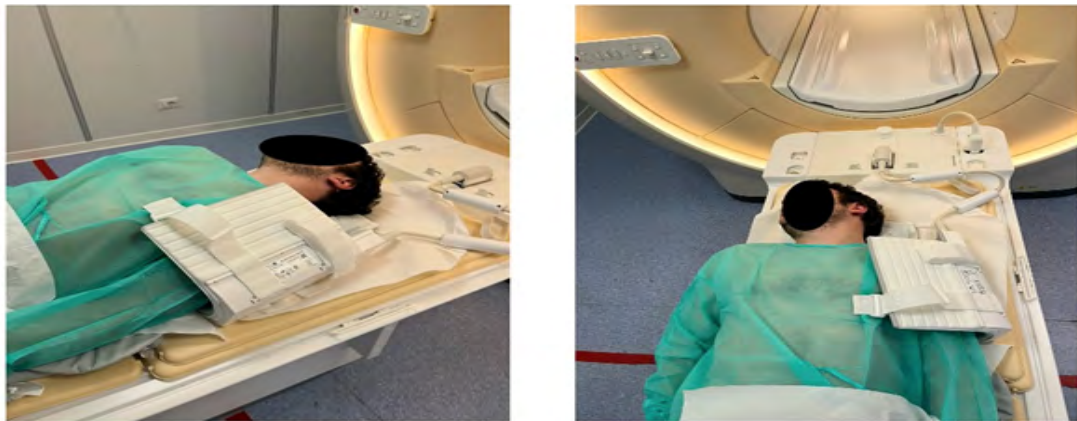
Positioning of the dStream Extremity Flex coil (Philips Healthcare, Netherlands Eindhoven) on the patient in the MRI of the shoulder.
